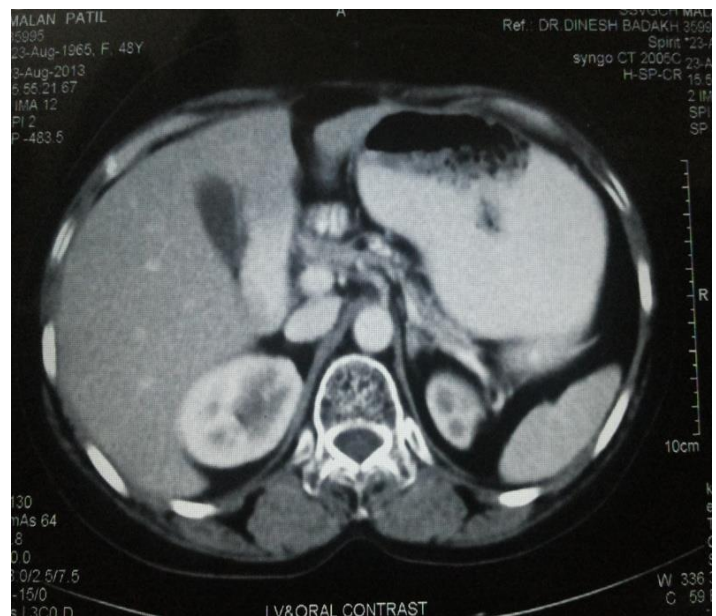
Postoperative CT scan 15 months after surgery and completed radiotherapy
